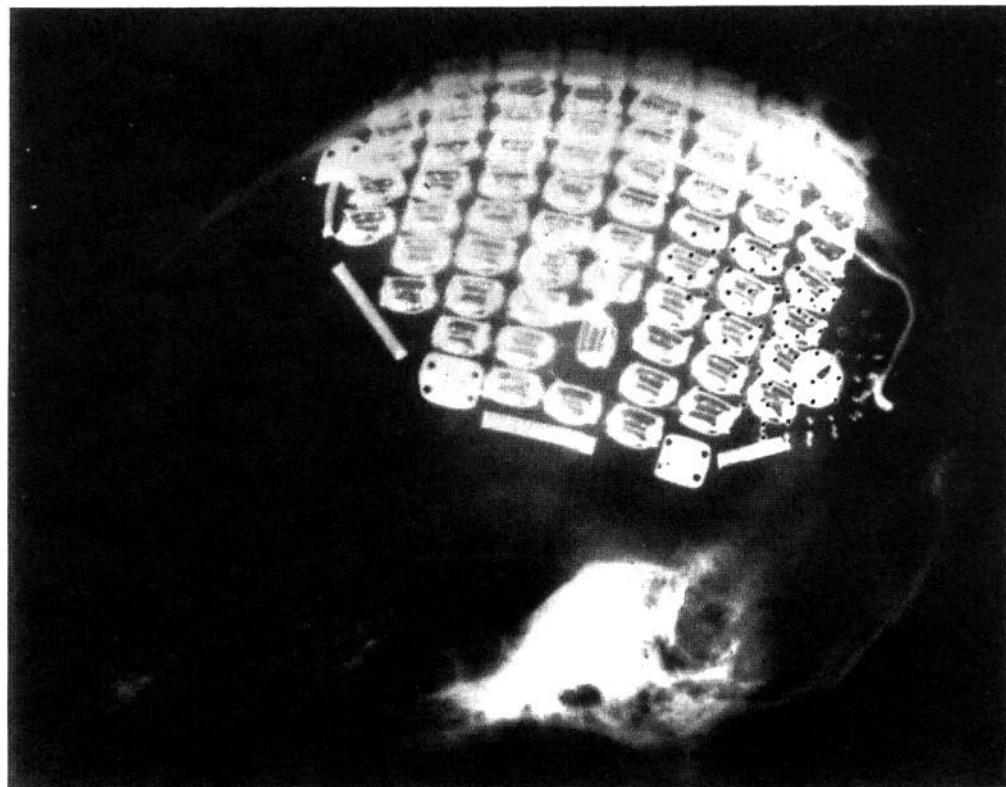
A lateral X-ray photograph of the electrical stimulation implant used by Brindley & Lewin (1968). The large white objects are an array of 80 radio receivers, embedded in silicone rubber and implanted extracranially. An array of 80 stimulating electrodes (each $800 \times 800 \mu\text{m}$) was positioned intracranially against the surface of the visual cortex using a cap of silicone rubber moulded to fit the contours of the cortical surface. The electrodes appear as an array of tiny dots on the right-hand side of the implant. The shadows of most of the dots were retouched in the original photograph and appear as black dots. Each radio receiver was connected to an individual stimulating electrode by a fine, insulated wire. Radio signals could be pulsed to any receiver by means of a transmitting coil tuned to an appropriate frequency. Pulses were usually $200 \mu\text{s}$, delivered at an overall rate of 100 Hz. Reproduced with permission from Brindley & Lewin (1968).
